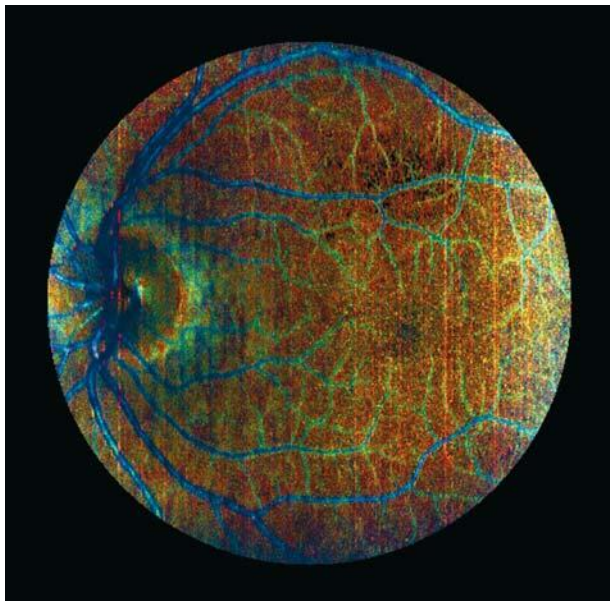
Pseudocolor LSLO map where the Doppler frequency shifts have been binned for low speed (red, $f < 400$ Hz), middle speed (green, $f = 400$ to 1000 Hz), and high speed (blue, $f > 1000$ Hz).
